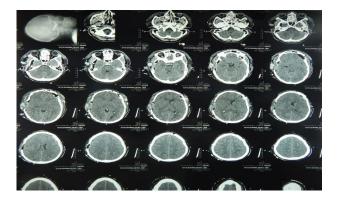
(A): Postoperative CT scan brain of case 4.
